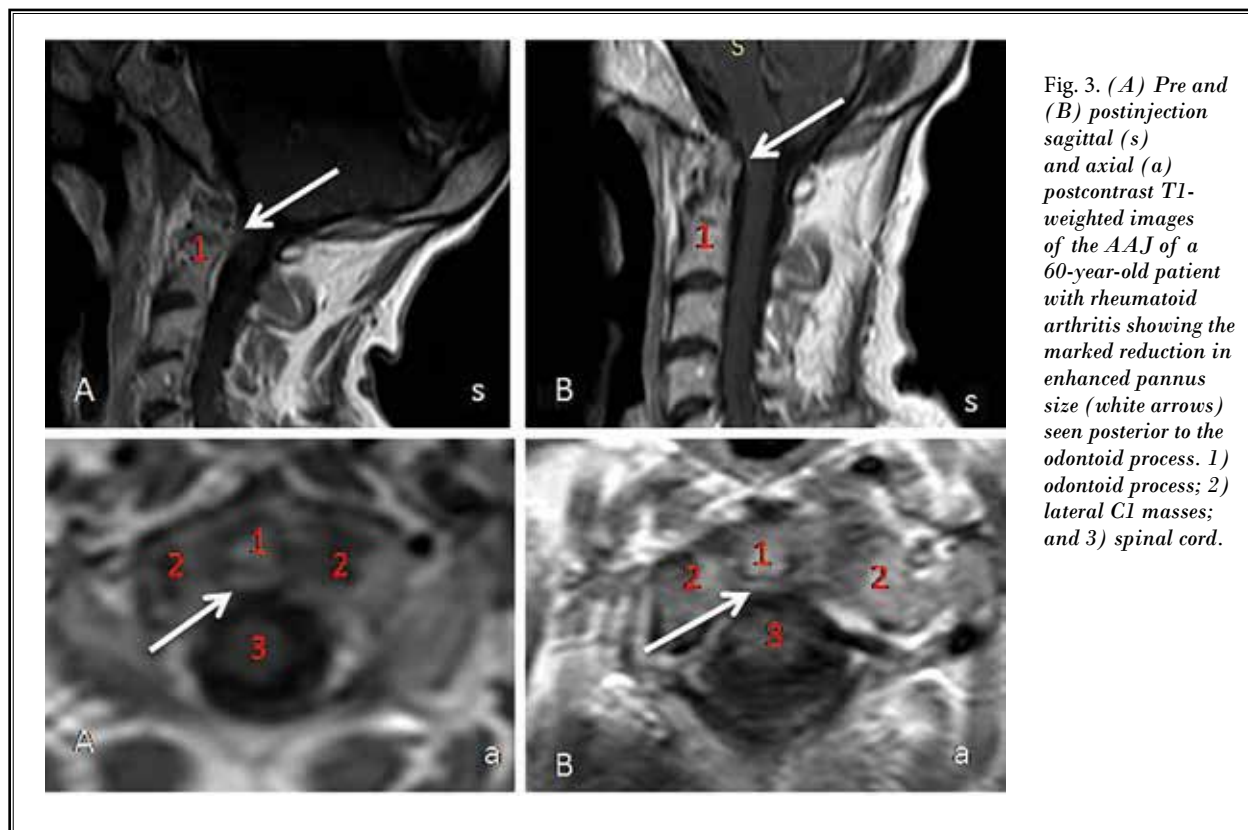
(A) Pre and (B) postinjection sagittal (s) and axial (a) postcontrast T1-weighted images of the AAJ of a 60-year-old patient with rheumatoid arthritis showing the marked reduction in enhanced pannus size (white arrows) seen posterior to the odontoid process. 1) odontoid process; 2) lateral C1 masses; and 3) spinal cord.
